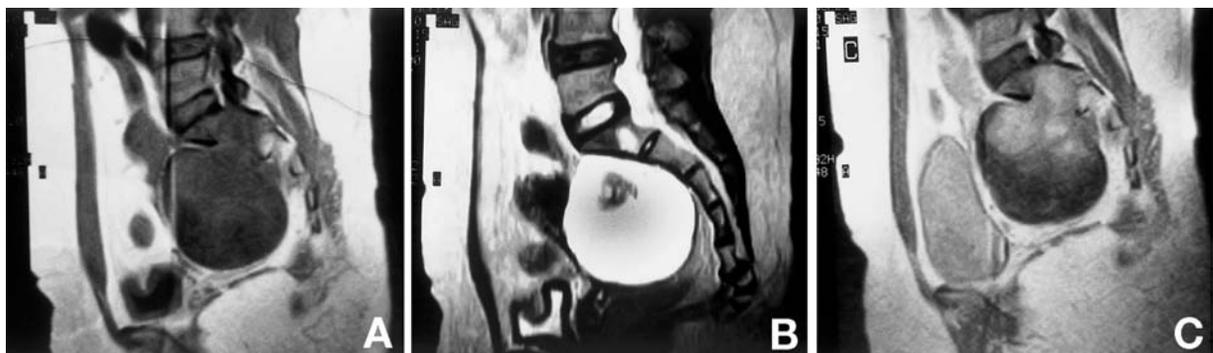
Magnetic resonance images showing a $8 \times 7 \times 7.5$ cm presacral lobulated mass as intermediate intensity on the T₁-weighted image (A), and high intensity on the T₂-weighted image with a well-circumscribed low signal intensity center (B). The tumor had expanded the S-1 neural foramen, entered the spinal canal, and encircled the right S-1 root epidurally. The intrapelvic mass was partially enhanced, and the foramen and spinal canal were totally enhanced by contrast medium (C).
